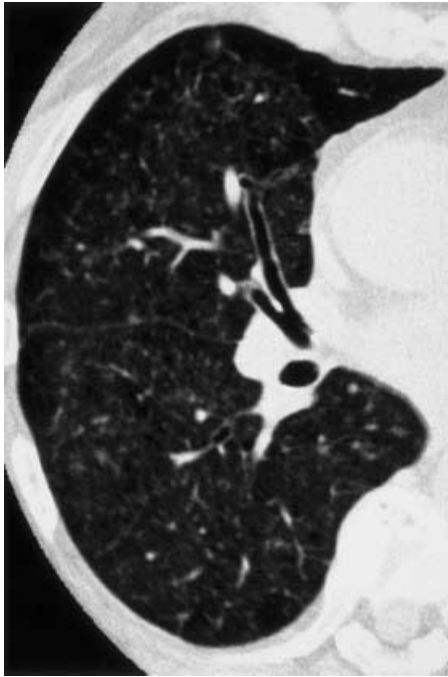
Respiratory bronchiolitis in a heavy smoker. Thin-section CT scan targeted on the right lung showing small ill-defined centrilobular nodules associated with ground-glass opacities that reflect macrophage accumulation in the distal air spaces and bronchioles
